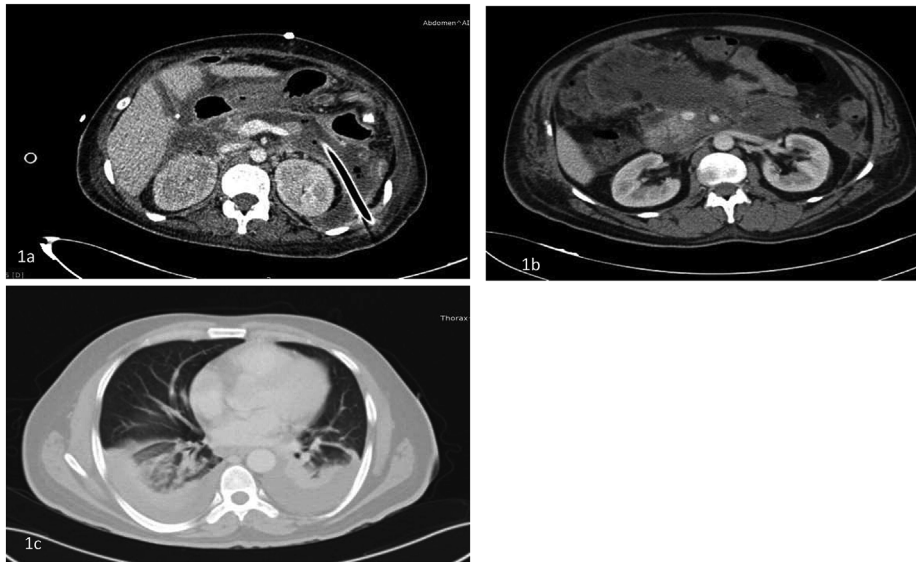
1a. Infected walled off necrosis in a patient with percutaneous catheter drain in situ who underwent percutaneous endoscopic necrosectomy, 1b. A contrast enhanced computed tomography (CT) scan of a patient showing features of acute necrotizing pancreatitis, 1c. CT scan of the chest of the same patient showing bilateral lung infiltrates after COVID-19.
